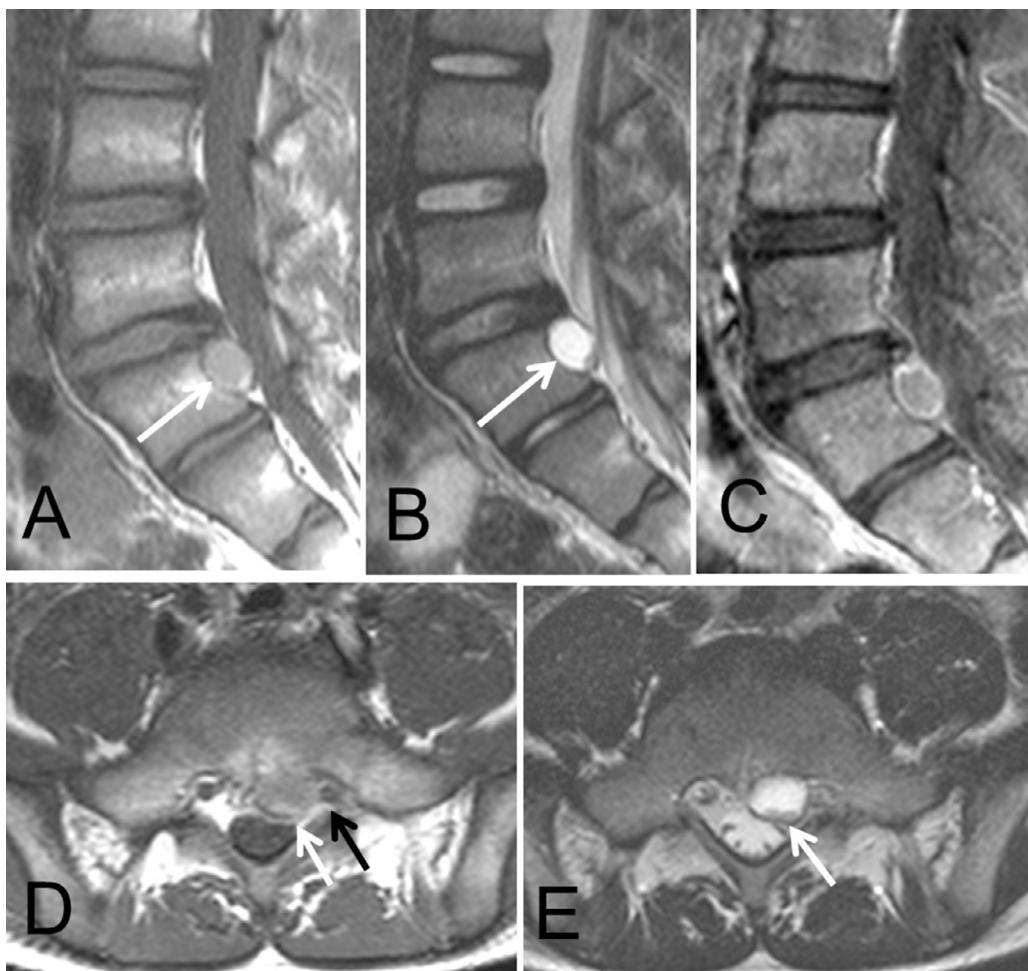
MRI with sagittal T1, T2, postgadolinium T1 as well as axial T1- and T2-weighted images (A–E). Cystic mass is seen ventrolateral to the thecal sac at the S1 level with peripheral enhancement. Signal features of T1 and T2 hyperintensity are related to subacute blood products (white arrows, A and B), with more focal blood clots/debris also noted to layer dependently (white arrows, D and E). There is mass effect on the left S1 nerve root (black arrow, E). Note the osseous remodeling of the dorsal margin of the S1 vertebral body indicating chronicity.
